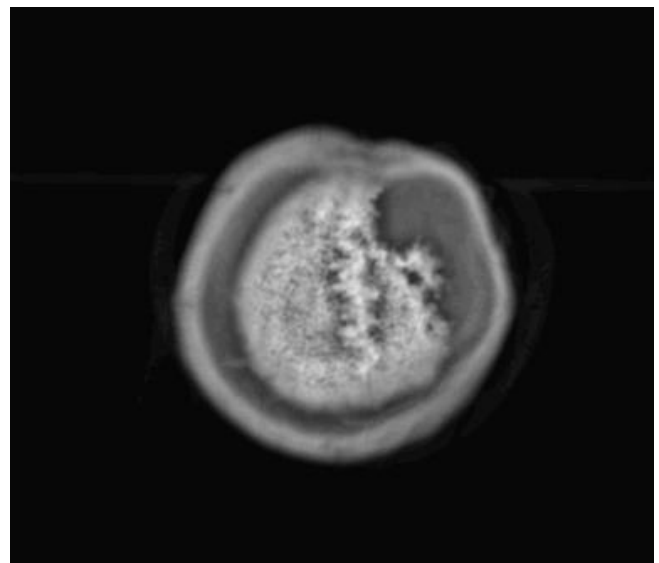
Skull defect in magnetic resonance imaging
